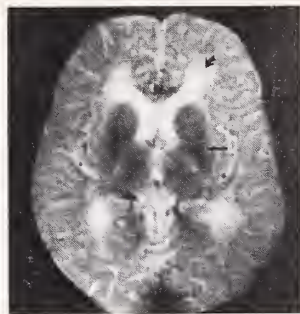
T2-weighted image showing decreased signal intensity regions in the basal ganglia (straight arrow) and increased signal intensity anterolateral to the frontal horns (curved arrow).
